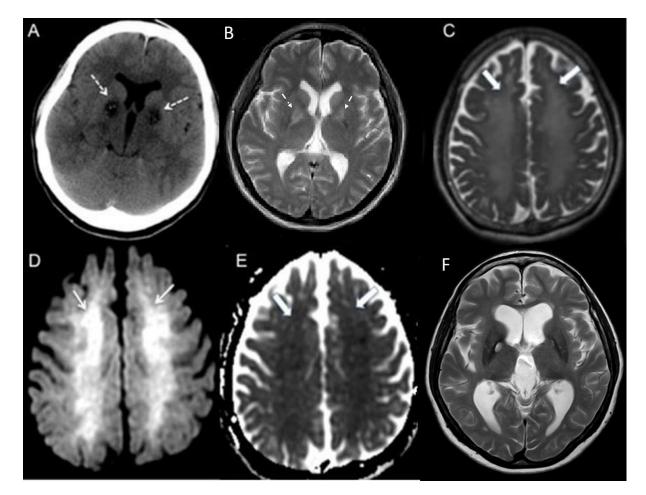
Neuroimaging in acute and delayed phases of carbon monoxide poisoning. A: At presentation, axial non-contrast computed tomography of brain showed bilateral symmetrical hypodensities in globus pallidus (dashed white arrows). B: On day 7, axial T2W MRI post-exposure showed bilateral hyperintensities in globus pallidus (short dashed white arrows). C: On day 35, axial T2W MRI showed bilateral confluent hyperintensities in cerebral white matter (thick white arrows). D and E: On day 35, ADC showed confluent DWI (b = 1000 s/mm³) hyperintensities in bilateral centrum semiovale (white arrows) with corresponding low signal on ADC (thick white arrows), indicating restricted diffusion. F: At 5 years postexposure, axial T2W MRI showed widened sulci and increased ventricular dilatation (compared with 1B), indicating volume loss. ADC: Apparent diffusion coefficient; DWI: Diffusion-weighted image; T2W MRI: T2-weighted magnetic resonance image
